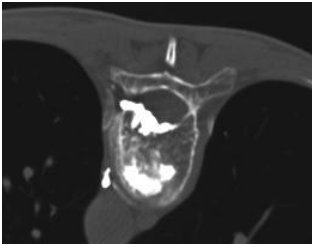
CT anterior epidural space leak
